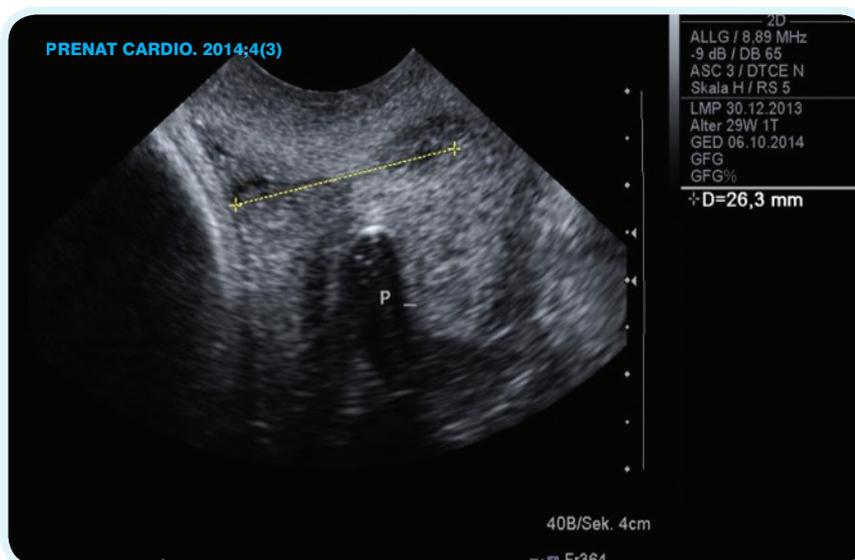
Transvaginal sonography in a twin pregnancy demonstrating elongation of the cervical length without funnelling during the course of pessary treatment (shadow evoked by the pessary) at 28 gestational weeks
